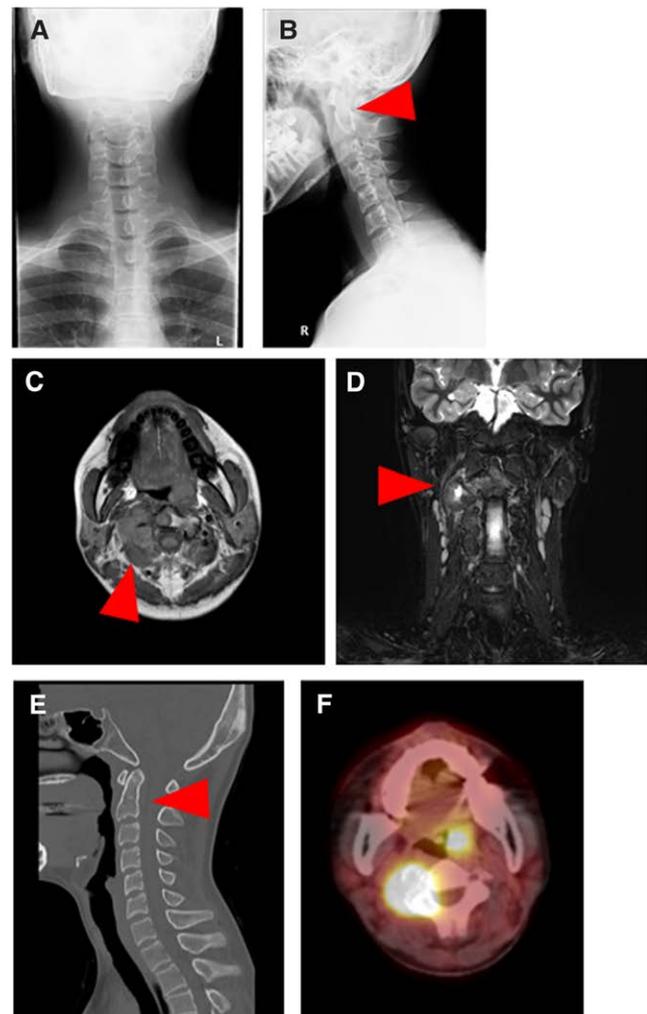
The representative images before the surgical treatment of Patient number 1 with the characteristics as described in Table 1. Coronal (A) and sagittal (B) radiographs of the cervical vertebrae showed erosion of the axis vertebra. Magnetic resonance image of the cervical vertebrae (C) and (D). The axial T1-weighted image shows the iso-intensity tumor mass in the axis vertebra (C). The coronal STIR image shows an iso- or high-intensity tumor mass in the axis vertebra (D). PET-CT shows an erosive lesion in the axis vertebra (E). Accumulation of SUV-max values = 8.00 (F). CT = computed tomography, PET = positron emission tomography, STIR = short TI inversion recovery, SUV-max = maximum standardized uptake.
